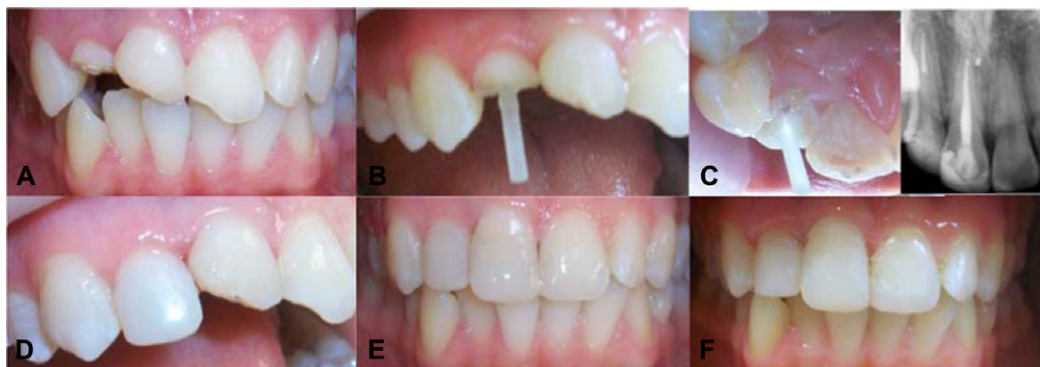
A clinical case representing insertion of fiber post and restoration of three traumatized teeth (A) preoperative, (B) buccal view of fiber post, (C) palatal view of fiber post and X-ray, (D) completed restoration, (E) 1 year, and (F) 2 year.
